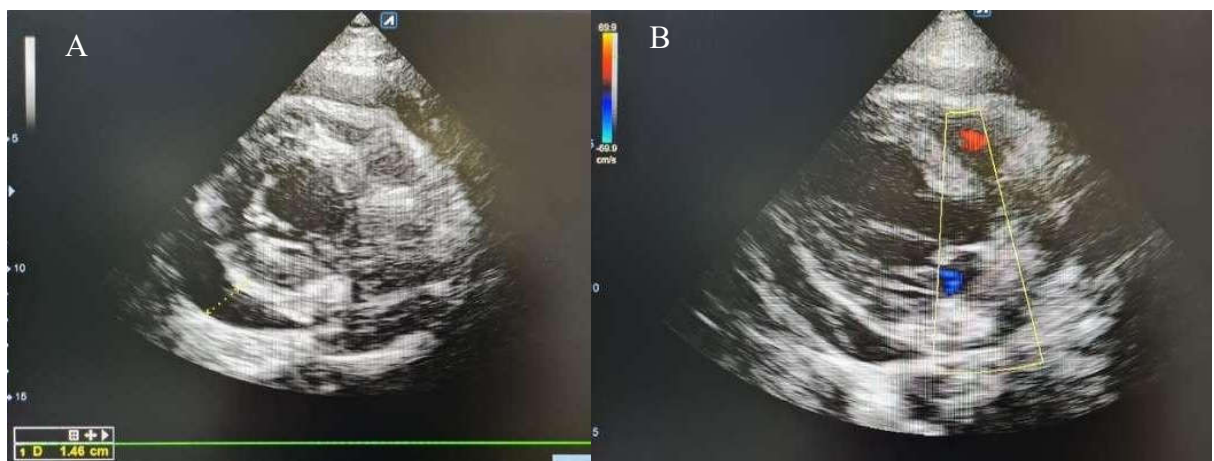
Results of Transthoracic Echocardiogram (TTE) 3 days after PCI. Transthoracic Echocardiography results showed normal left ventricular ejection fraction, no regional wall motion abnormalities, moderate pericardial effusion, and thickening of the pericardium. (A). Short Axis View. (B) Parasternal long axis view.
